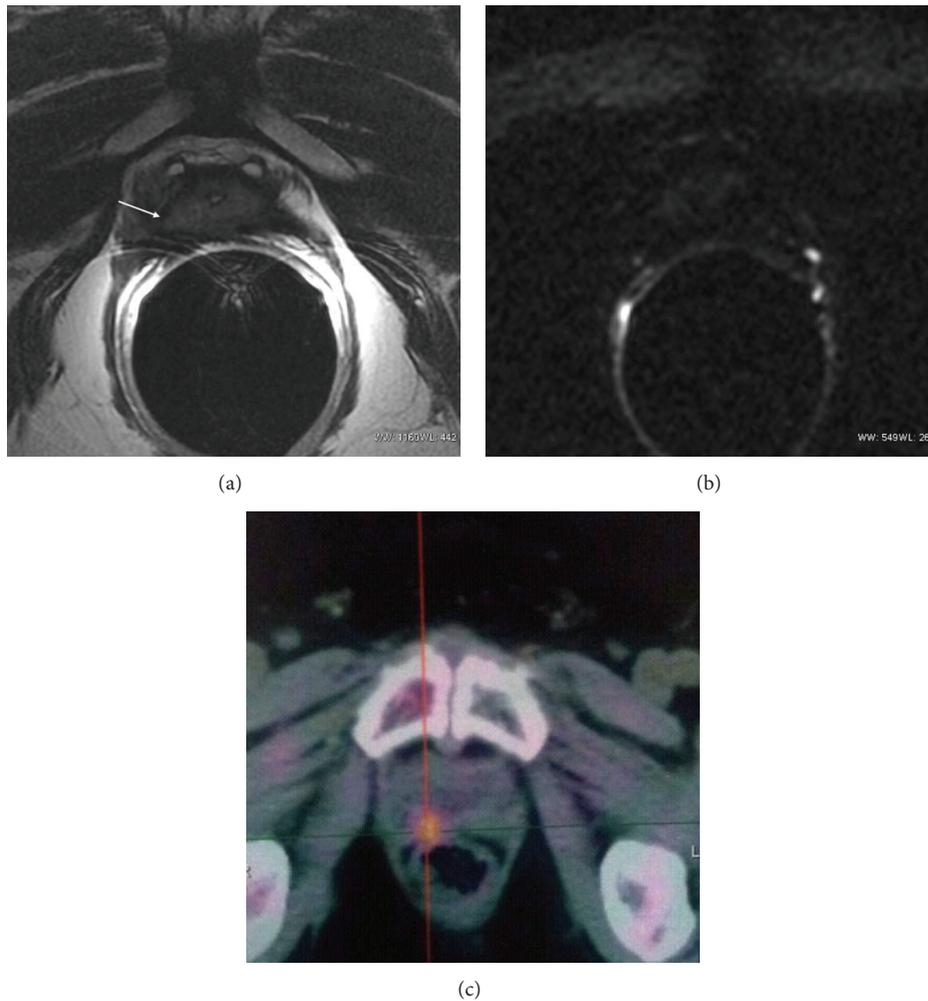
DWI, false negative. Patient with a glandular apical residual prostate tissue and a progressive increase of PSA_t (last value before DWI: 0.61 ng/mL). The T2-weighted image (a) shows the minimal residual prostate tissue with a small bulging in the right paramedian site (arrow). No detectable hyperintensity was visualized in DW image (score DWI = 0, (b)); 18F-choline PET-CT (c) showed a focal uptake at the site of the described bulging. The post-RT decrease of PSA_t under 0.2 ng/mL was a further standard of reference in this case.
